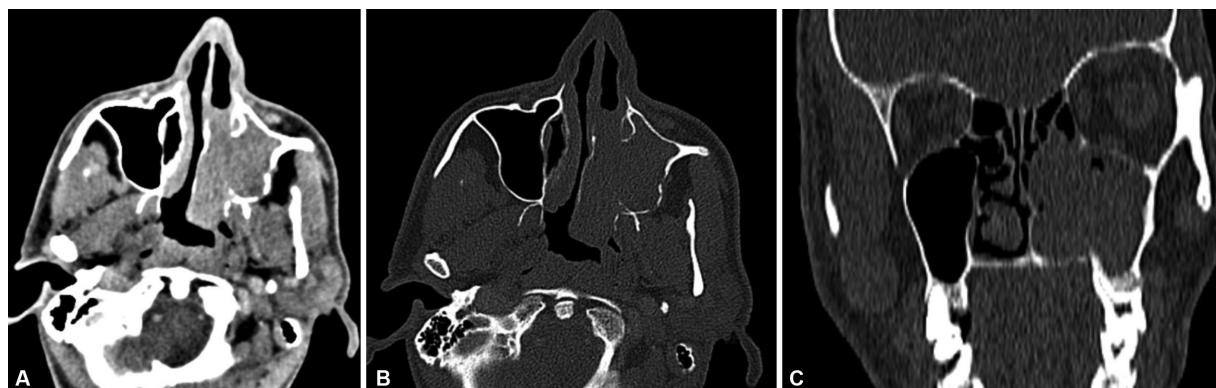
Sinonasal undifferentiated carcinoma. (A) Axial contrast computed tomographic image in soft tissue window shows enhancing mass in the left maxillary sinus invading the left nasal cavity. (B) Bone window image better depicts the erosion of the posterior wall of left maxillary sinus, and the left medial pterygoid plate. The turbinates are destroyed. (C) Coronal reformatted bone window image shows erosion of the hard palate.
